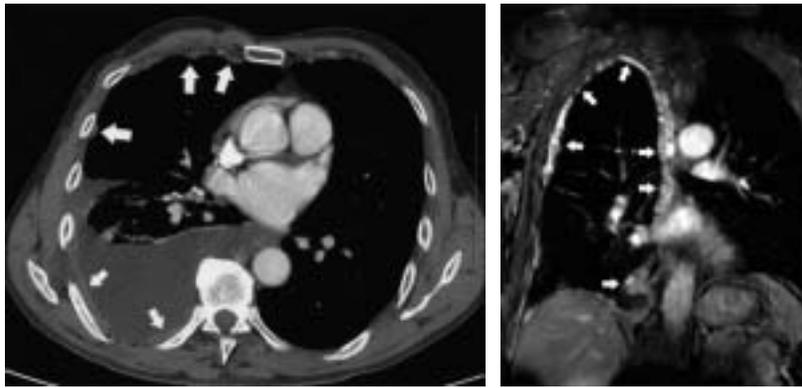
Left, Contrast-enhanced computed tomogram at the level of the left atrium shows a right pleural effusion with foci of pleural nodularity (large arrows) and thickening (small arrows). Right, Coronal gradient-echo magnetic resonance imaging obtained after gadolinium administration showing irregular pleural enhancement involving the mediastinal, costal, and diaphragmatic pleural surfaces (arrows) diagnosed by thoracoscopic biopsy as mesothelioma.
